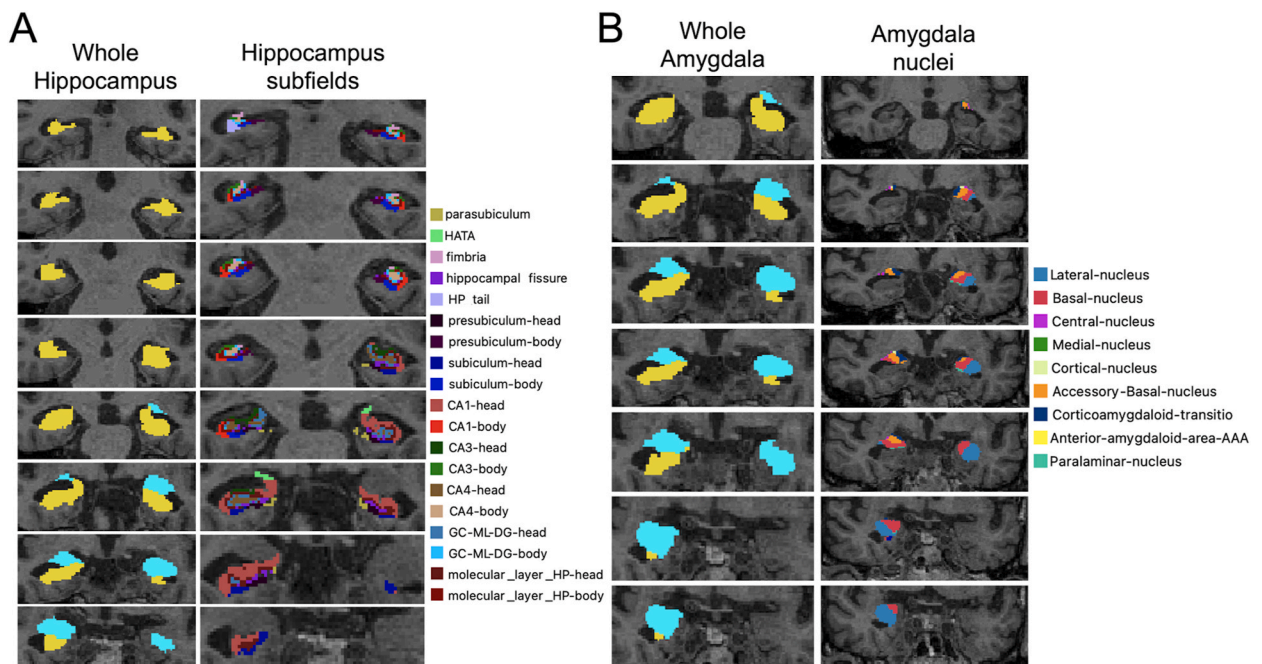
Representative images show the MRI segmentation of the amygdala, hippocampus, and their subregions. (A) The segmented whole left and right structures of the hippocampus are depicted in yellow, and their parcellation into specific subfields. (B) The segmented whole left and right sub-structures of the amygdala are depicted in light blue, and their parcellation into 9 nuclei. The images are presented in the neuroradiological convention.
